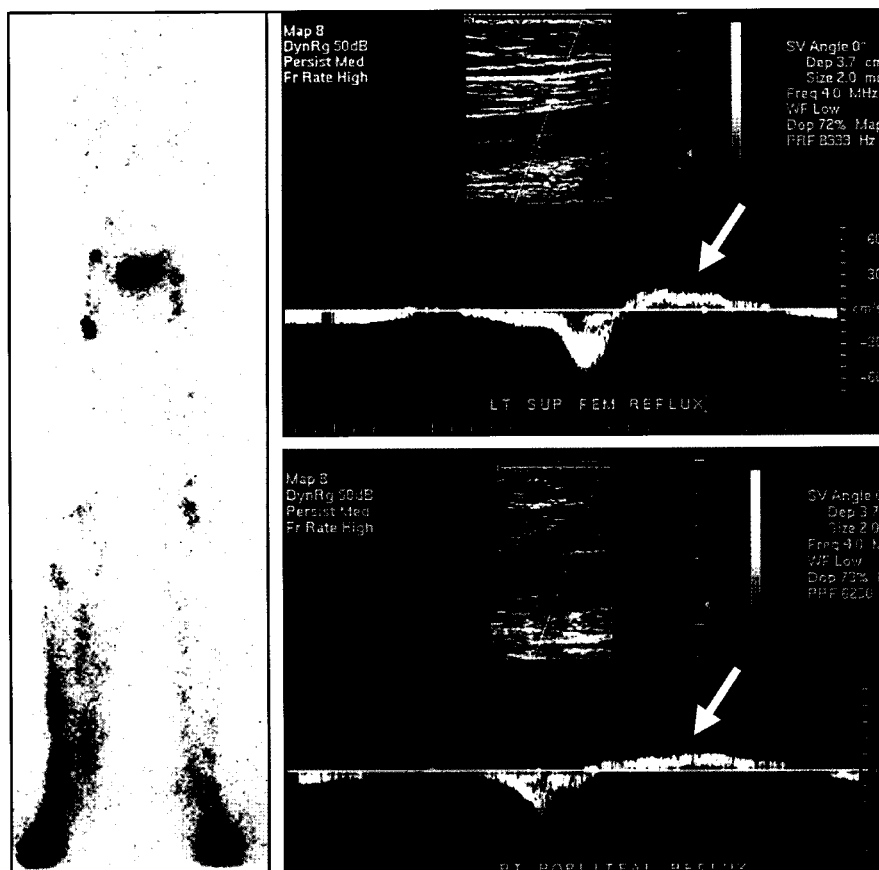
Family 4: Abnormal LAS(left) in another ML brother (V-2) of the subjects depicted in Figs. 4A-E showing delayed tracer transport, irregular lymphatic channels, late tracer pooling and poor regional nodal visualization. Doppler ultrasound venogram (right) performed to evaluate prominent superficial venous varicosities of the legs since infancy, displays severe reflux throughout the superficial and deep venous system of the lower extremities including left femoral (upper) and right popliteal veins (lower) seen here as a prolonged reverse flow phase (arrows).
